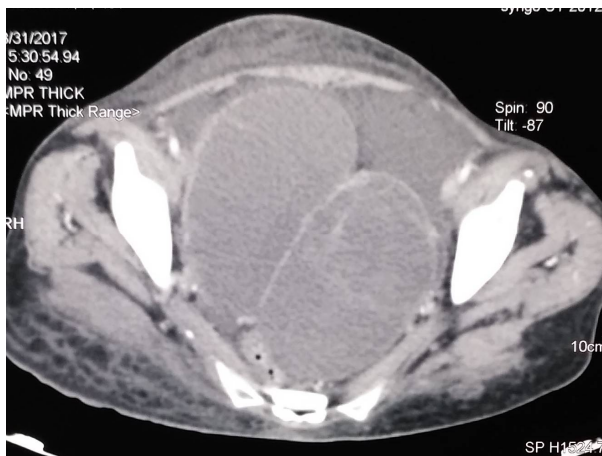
and 1b (a) Contrast enhanced axial CT image showing heterogeneously enhancing infiltrative gall bladder mass with involvement of adjacent liver parenchyma, 2nd part of duodenum, proximal common hepatic duct and pancreatic head. (b) Contrast enhanced axial CT image showing large lobulated, multiloculated mass lesions with enhancing internal septations arising from bilateral adnexal regions.
